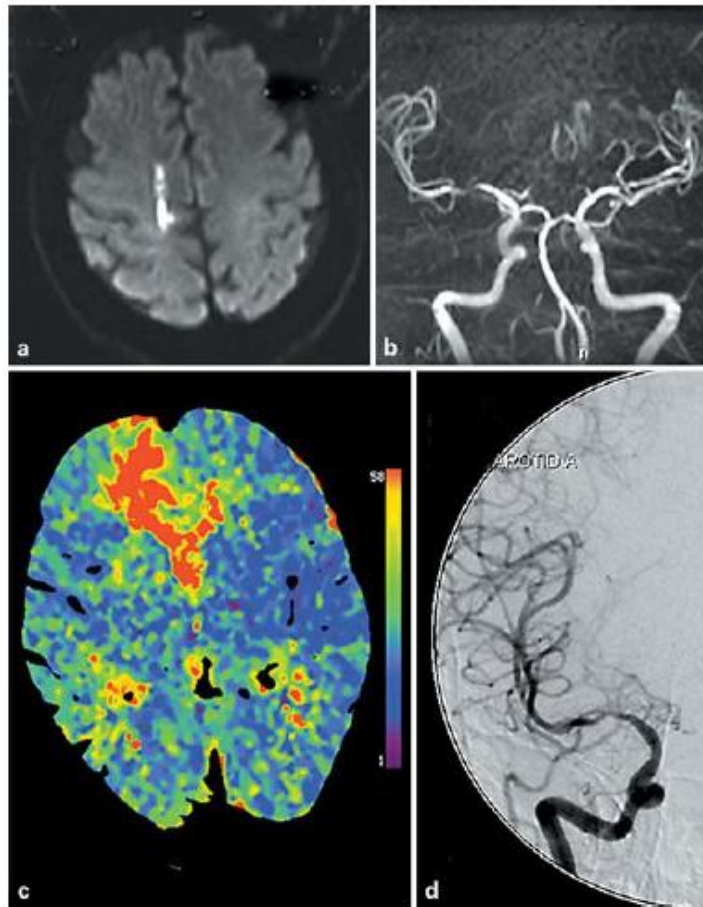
a Diffusion-weighted MRI revealed high signal intensity lesions in the right watershed territory between the ACA and MCA. b Magnetic resonance angiogram showed severe focal stenosis of the right MCA and absence of bilateral ACA. c Perfusion CT showed delayed mean transit time in the right anterior frontal lobe, the right anterior and posterior border zone, and the right basal ganglia. d Digital subtraction angiography showed severe focal stenosis of the M1 segment of the right MCA and absence of the ACA. The right border zone (between the ACA and MCA) shifted internally, suggestive of the right ACA territory being compensated partially by the leptomeningeal collateral vessels from the right MCA.
